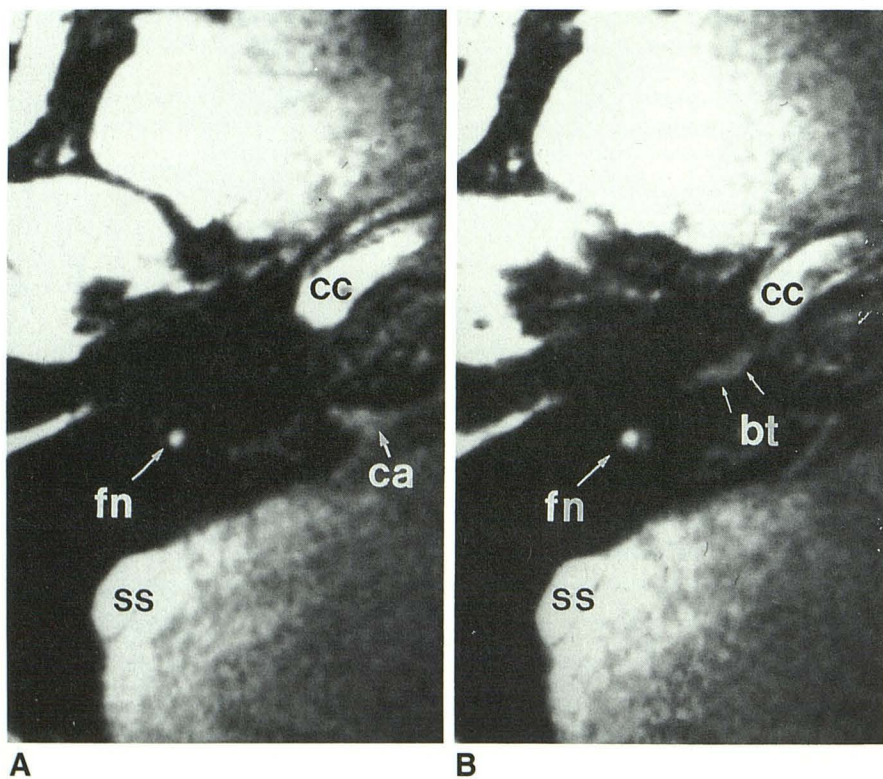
Axial 3DFT MR images, 33/7/1 (256 × 256 matrix and 1.0-mm slice thickness). See key for abbreviations.
